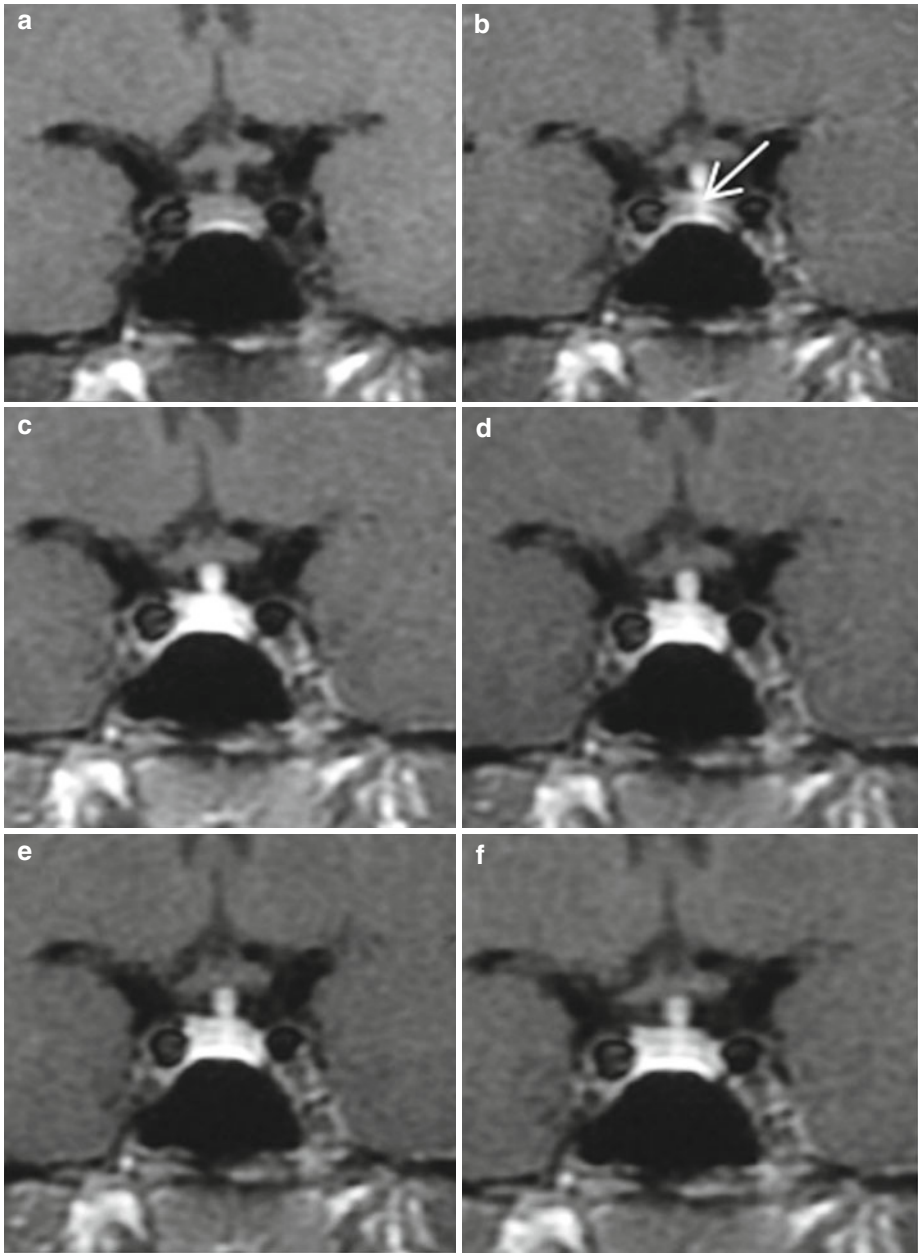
Dynamic MRI of the normal pituitary gland. (a) Before contrast injection. (b) About 30 s later, opacification of the pituitary stalk and the secondary capillary bed (arrow). (c) At 60 s, the enhancement of the pituitary gland is intense and homogeneous. (d–f) Slow decrease of enhancement intensity
